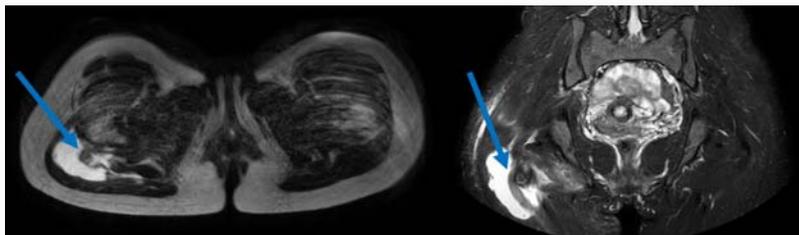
MRI: MRI scans in axial and ap show the elongated sciatic nerve (blue arrows) with the surrounding hematoma/fluid collection.
